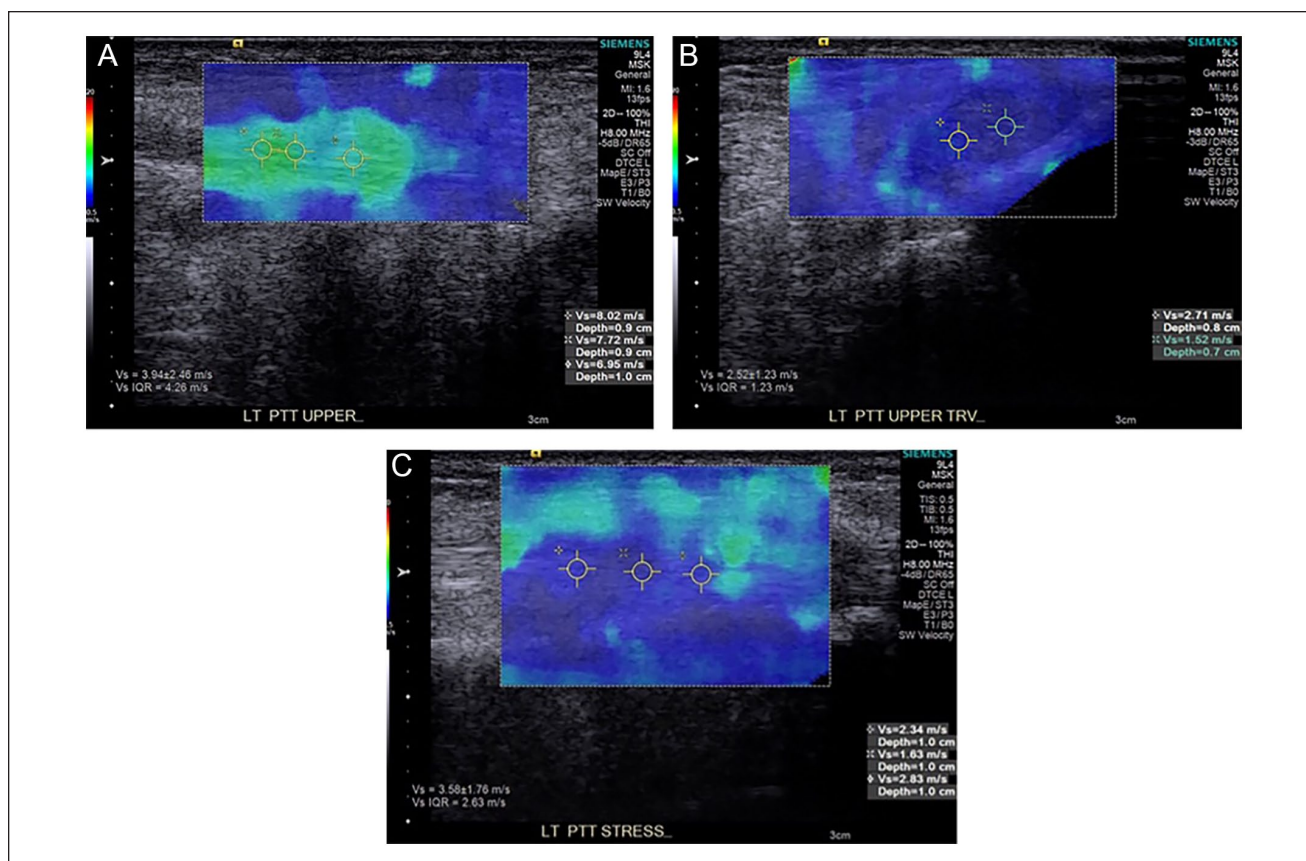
Representative ultrasound shear wave elastography (US SWE) images of the supramalleolar (upper) posterior tibial tendon in an asymptomatic flatfoot. (A) Long axis US SWE image at rest demonstrates intermediate shear wave velocities (SWVs) in green. (B) Short axis (transverse) US SWE image in the same region at rest shows lower SWVs in blue. (C) Under stress, long axis US SWE image in the same region shows decreased SWVs in blue.
